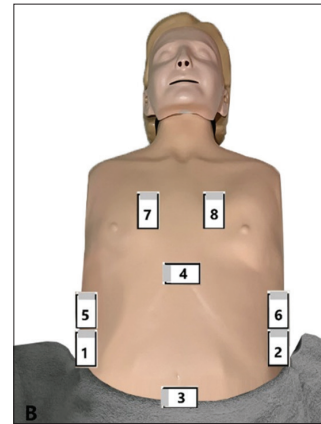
Extended Focused Assessment of Sonography for Trauma (e Focused Assessment of Sonography for Trauma). Assessment of hemothorax (5 and 6) or pneumothorax (7 and 8) in addition to basic Focused Assessment of Sonography for Trauma assessment (1–4)
